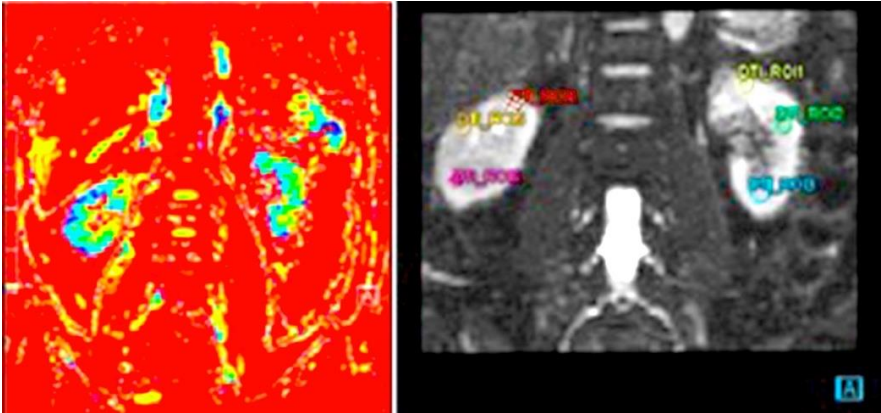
DWI image and ADC measurement on six different ROIs. A coronal DW-MRI and ADC map were obtained from a 68-year-old male volunteer with an eGFR of 70.65. Three ROIs were placed in the upper
